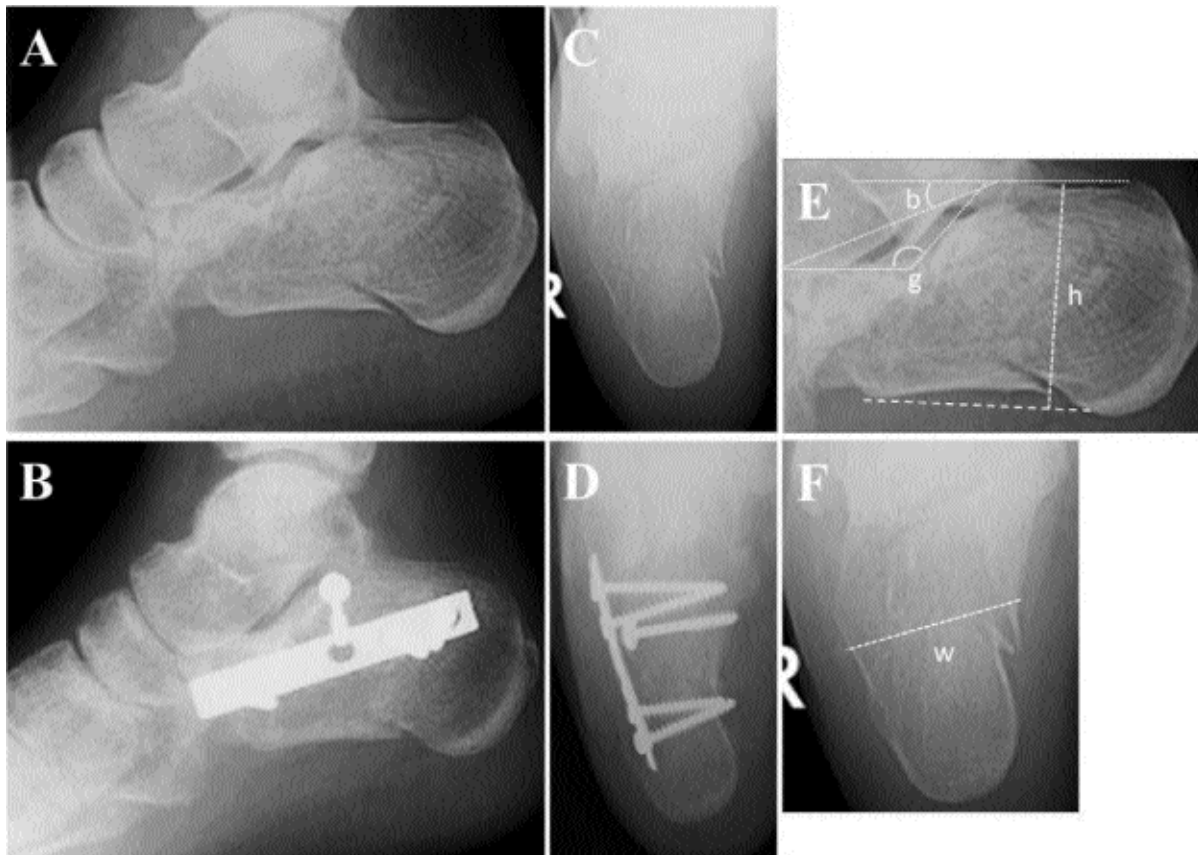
(A-F) Pre-operative (A-lateral,B-axial) and post-operative (C-lateral,D-axial) X-rays and the measurement (E-lateral,F-axial) method (b=Bohler's angle;g=Gissane's angle, h=height, w=width). Post-operative final X-rays showing healed fracture with increase in Bohler's angle and reduction in Gissane's angle, increase in height and decrease in width. Fixation of the body has been done with semitubular plate and the sustentacular fragment with latero-medial lag screw.
